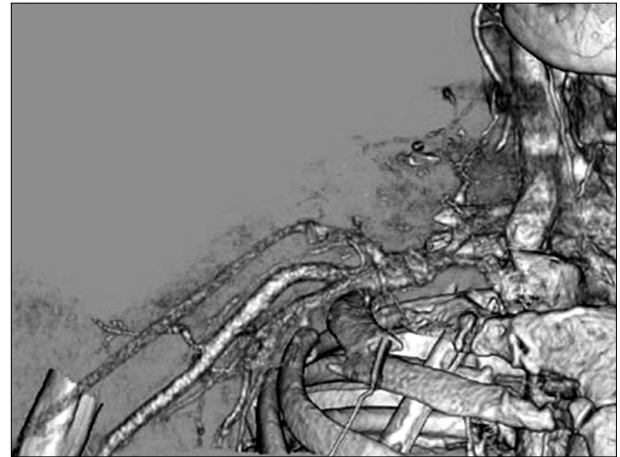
Follow-up chest computed tomography with 3-dimensional reconstruction shows no venous compression or engorgement on right upper extremity.
